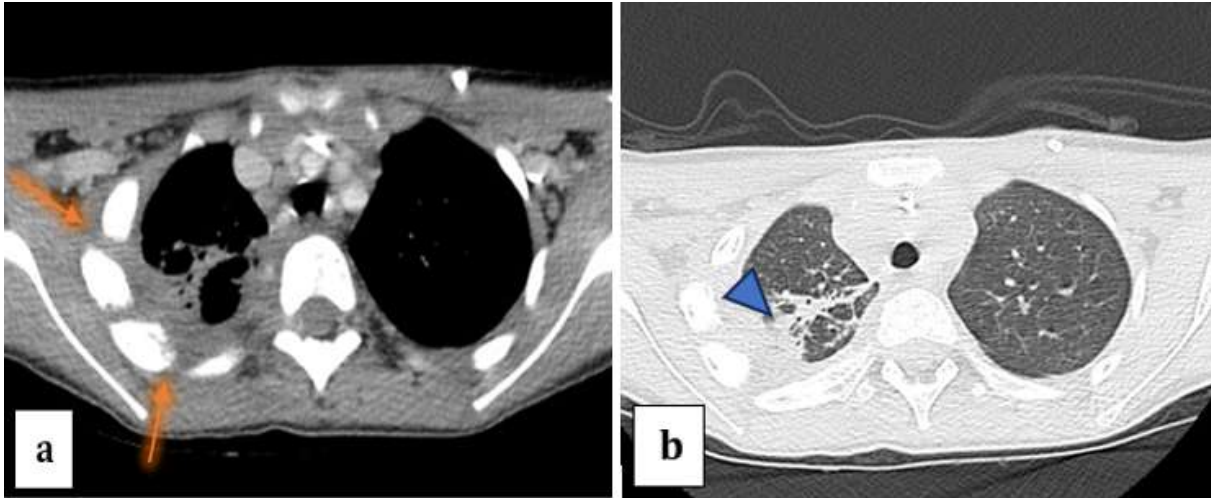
A follow-up CT scan displayed on the mediastinal (a) and lung (b) window setting showing regression of right parietal thoracic mass (arrow) and upper lobar condensation (arrowhead).
